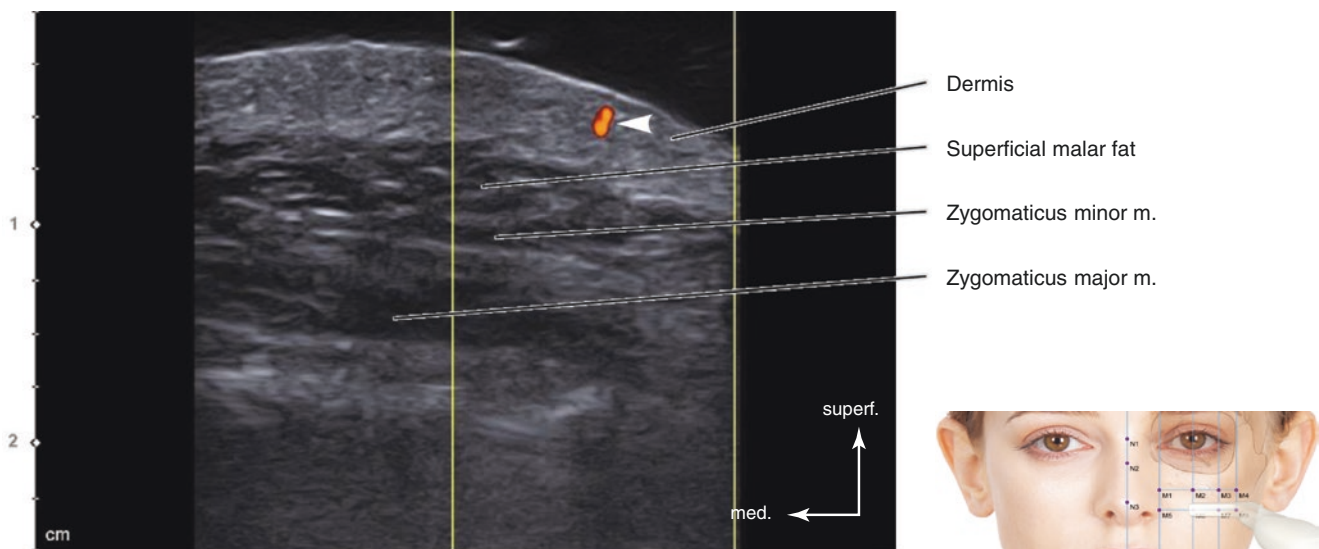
Ultrasonography on the intersection point of TL5 and PL3 (M7). Doppler mode, (transverse view, 15 MHz by linear transducer) (arrow-head: perforator). (Published with kind permission of © Hee-Jin Kim 2020. All Rights Reserved)
